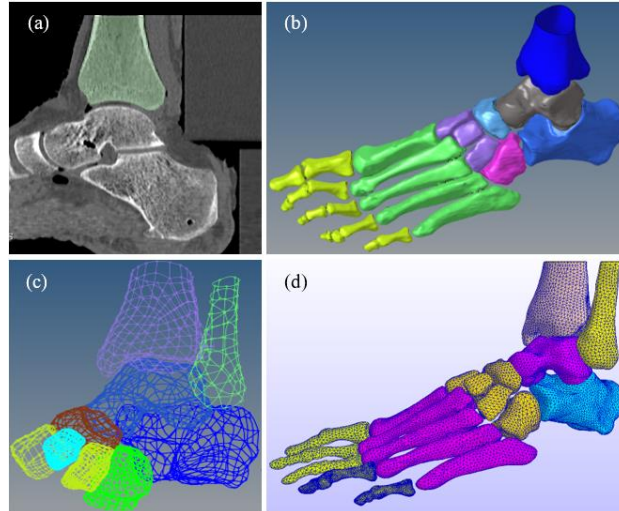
The pictures show how to create the foot bony segments from CT scan images. (a) on CT scan images, the bone was created separately. (b) the created bone segments were imported into Geomagic Design X to create geometric model as (C) figure. (d) Then, the geometric models were imported into Hypermesh to create meshed foot model.
